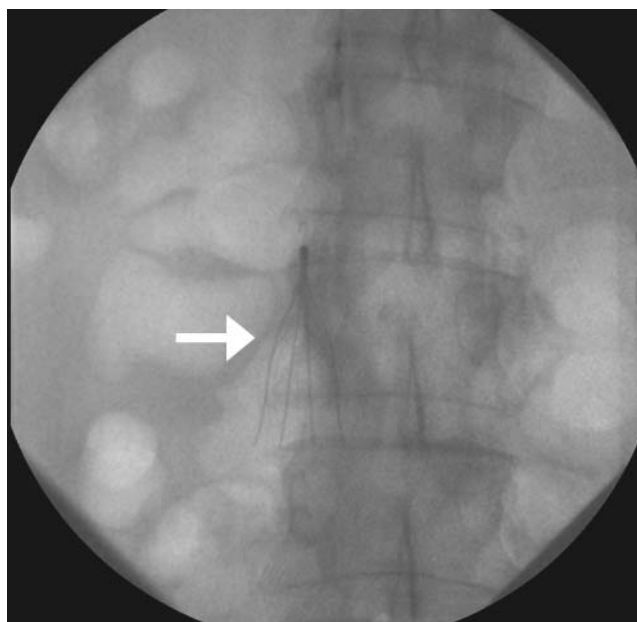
A 65-year-old female following intracranial aneurysmal clipping developed a pulmonary embolus but was unable to receive anticoagulation because of the recent intracranial surgery. Thus, a retrievable caval filter was placed. A plain film following filter insertion demonstrates a retrievable Cook Celect filter (Cook Medical, Bloomington, IN) within the infrarenal cava without any tilt (arrow).
